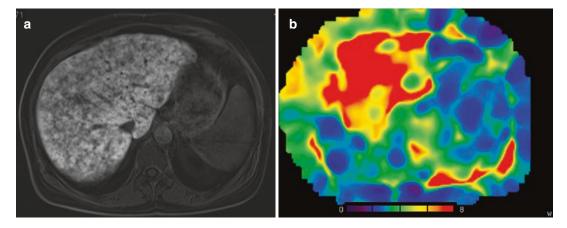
A 47-year-old female patient with sarcoidosis. Postcontrast T1W MR images demonstrate heterogeneous enhancement of the liver (a). Liver stiffness was 9.9 kPa on MR elastography consistent with involvement (b)
